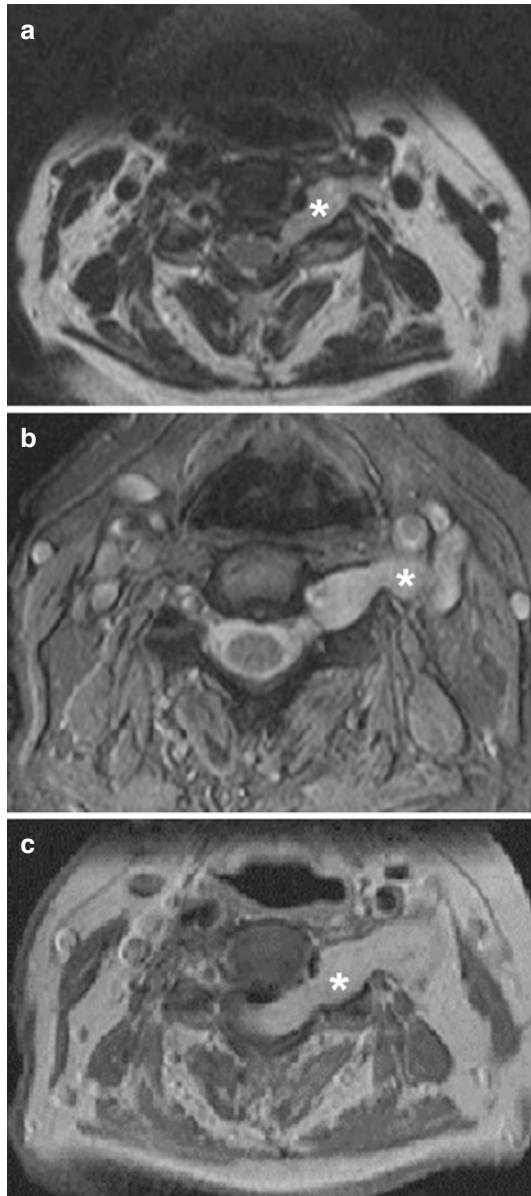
Imaging of an 84-year-old female patient with left-sided radiculopathy and mild quadriplegia. She was diagnosed with a left-sided C3/4 dumbbell tumor (asterisk). The tumor was followed for 3 years where it showed progressive growth. (a) Initial T2-weighted axial MRI of the cervical spine showing homogeneously hyperintense dumbbell lesion in C3/4 foramen on the left side. (b) T2-weighted axial MRI of the cervical spine at 1-year follow up showing progressive growth of the extraspinal tumor component. Since the patient was clinically stable, surgery was not indicated. (c) Axial T1-postcontrast MRI of the cervical spine at 3-year follow-up showing dumbbell lesion with intense contrast enhancement and progressive intraspinal tumor growth with compression of the spinal cord and myelopathy. At this point, the patient had worsening quadriplegia
